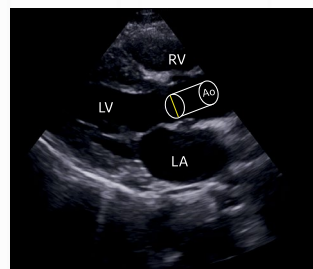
Parasternal long axis view, demonstrating the cylinder that represents the SV.
